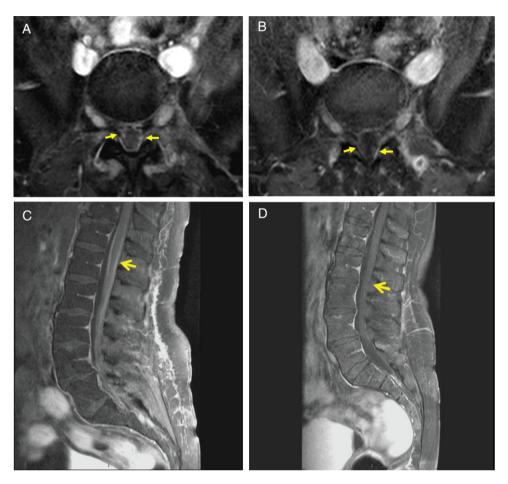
T₁-weighted fat-saturated gadolinium-enhanced MRI of the lumbosacral spine, Before treatment: (A) sagittal with full arrow referring to conus medularis surface enhancement, (B) axial with dotted arrow referring to intrathecal root enhancement. Five weeks after treatment: (C) sagittal image with full arrow referring to resolution of enhancement and (D) axial image with dotted arrow referring.
